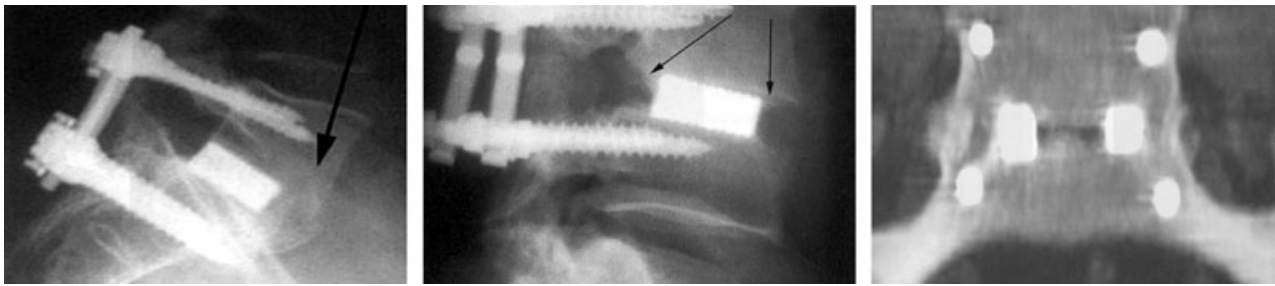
Radiographs in which arrows indicate trabecular bridges anterior, around and between the fusion cages.
